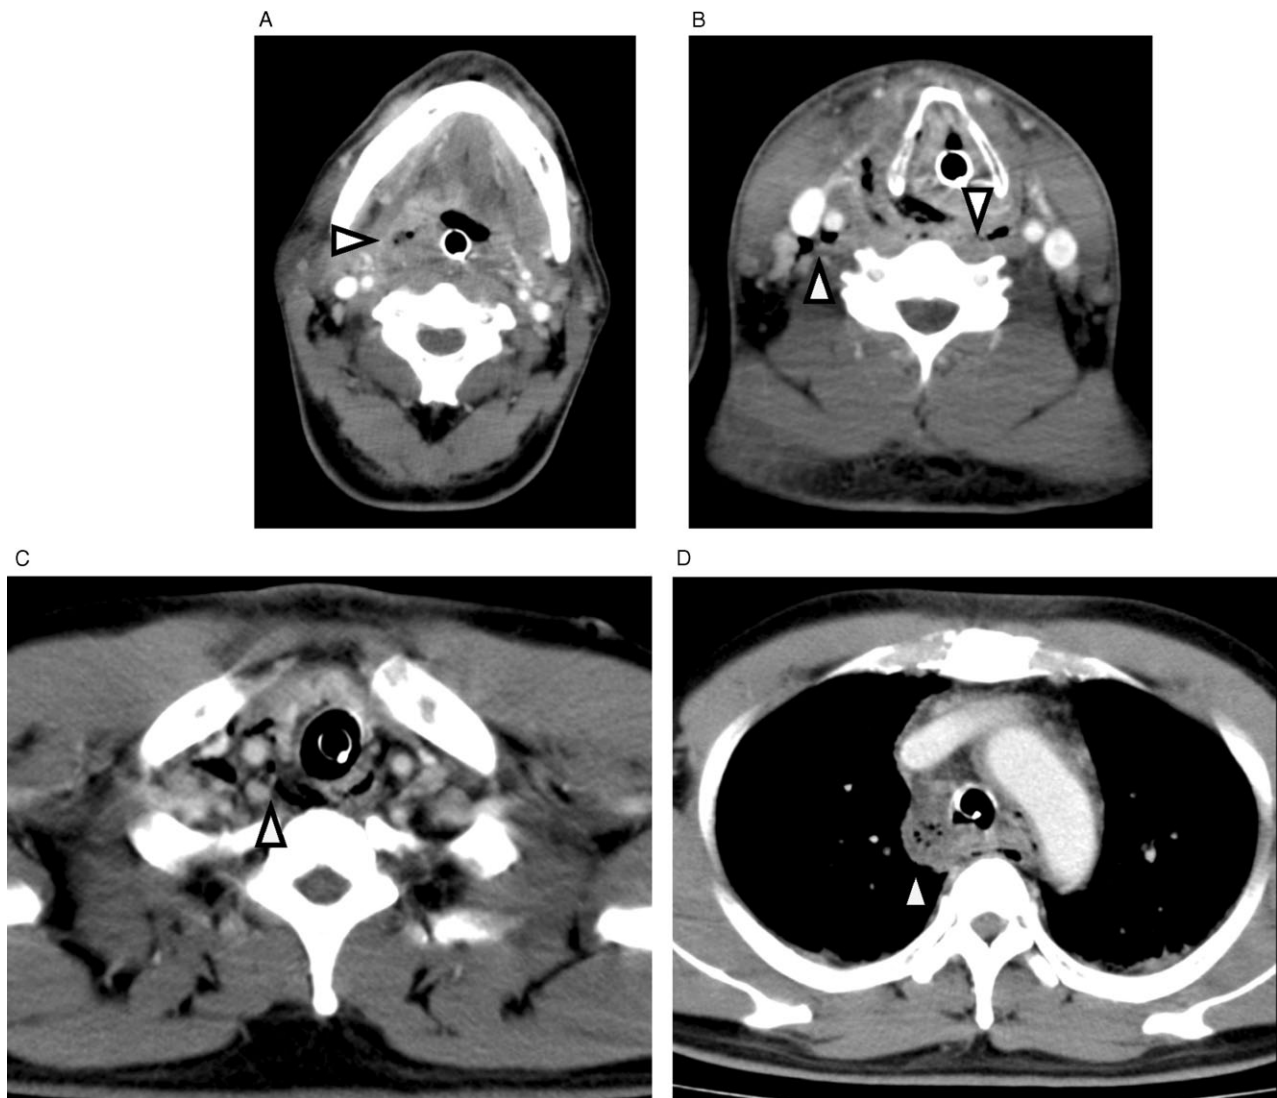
Contrast-enhanced computed tomography of neck and chest showing posterior mediastinitis due to tonsillar abscess (reproduced from Sumi (2013),⁵³ “Current treatment for burn injury”). A, Diffuse thickening and gas collection in retropharyngeal space. B, C, Diffuse thickening and gas collection in carotid and danger space. D, Diffuse thickening of mediastinal fat and gas collection in posterior mediastinum.
